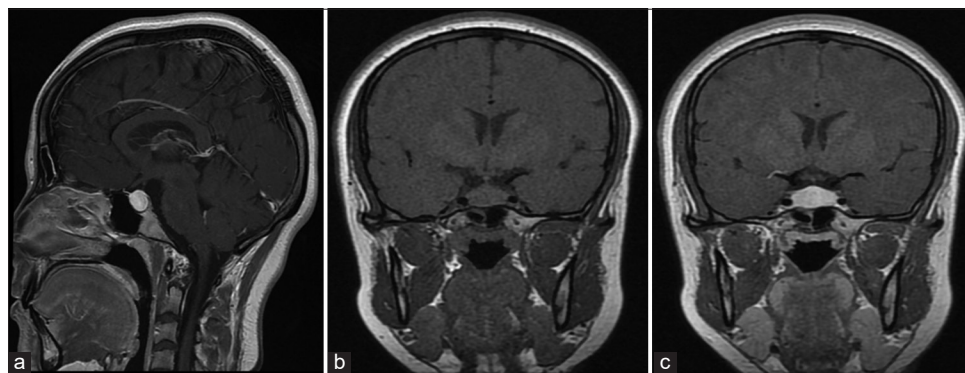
Hypothalamic-pituitary MRI of patient number 1 before corticosteroid treatment, showing a homogeneous hypertrophy of the pituitary gland with high contrast after gadolinium injection. (a) Sagittal section SE T1 after gadolinium injection (swelling of the antehypophyseal gland with homogeneous enhancement after contrast). (b and c) Pituitary dynamic sequence in coronal section SE T1 before (b) and after (c) gadolinium injection.
